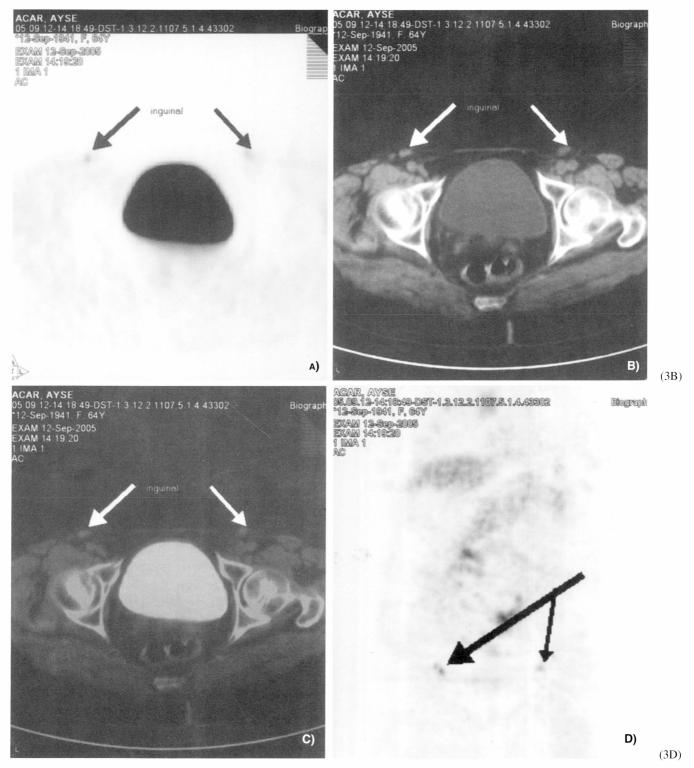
Inguinal lymph node lesions in the patient, (A) axial PET scan (B) axial CT scan (C) axial fused PET-CT scan (D) coronal PET scan showing slightly increased FDG uptake.
